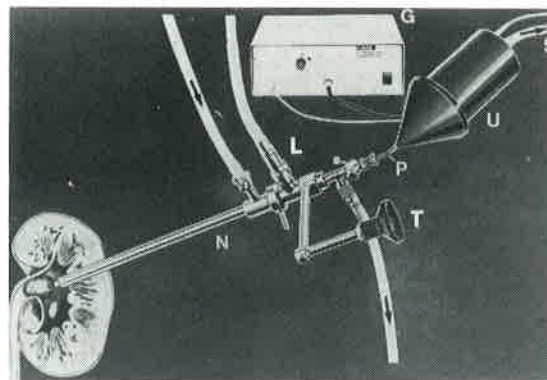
The percutaneous nephroscope with ultrasound lithotripter in situ. The tip of the sonotrode is in contact with a renal pelvic stone. The arrows indicate the direction of flow of the irrigating fluid.
